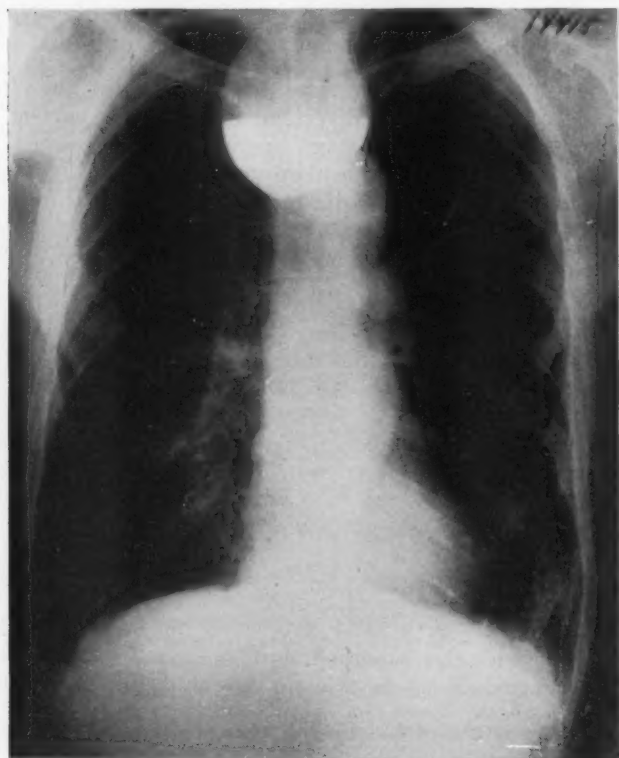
The X-ray film of another large pharyngoesophageal diverticulum is reproduced. A fluid level of barium is clearly seen in the sac itself.
